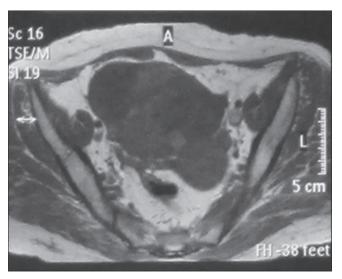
MRI of ovarian mass
